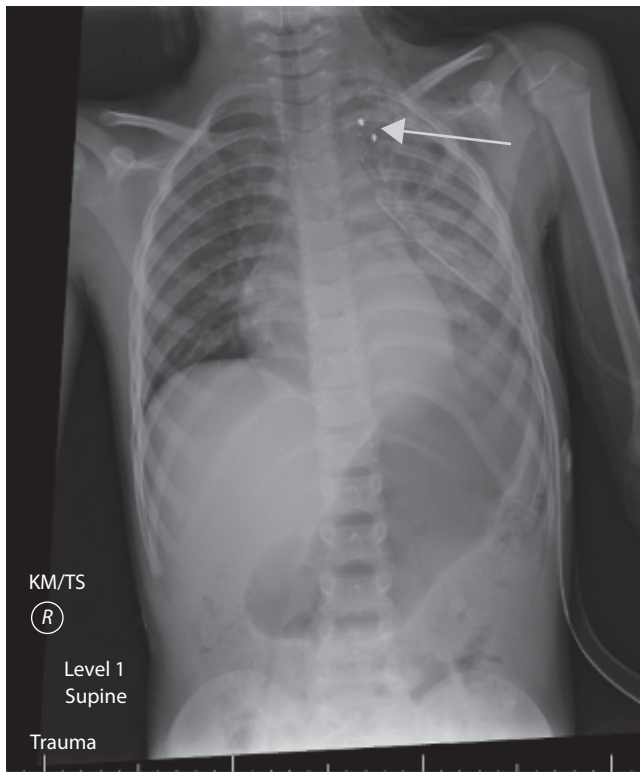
Plain radiograph of 6-year-old male with gunshot wound to the left chest (arrow to show presence of shrapnel). Patient underwent tube thoracostomy with evacuation of hemo/pneumothorax.
